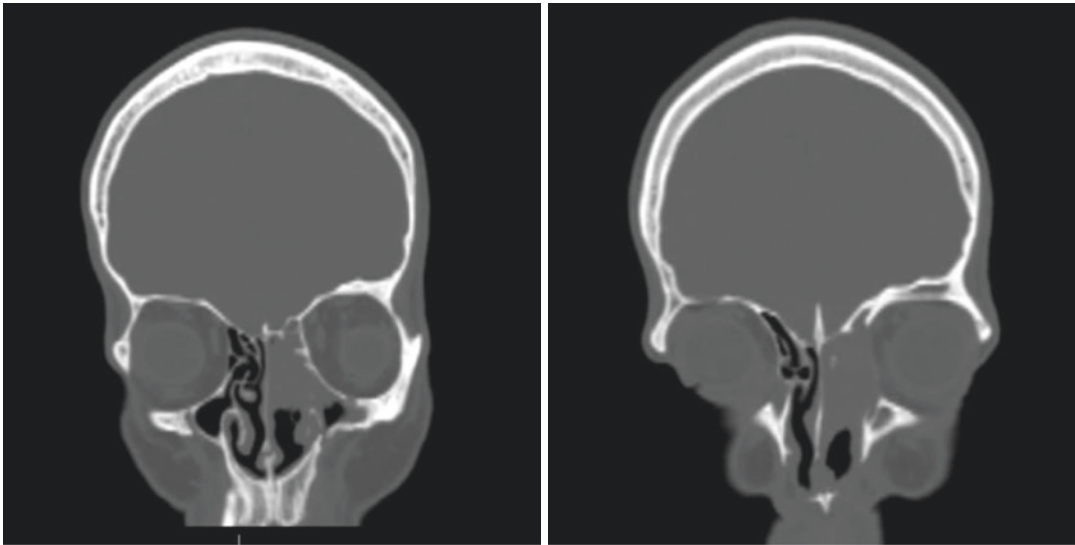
Coronal CT scans of the patient's sinuses
